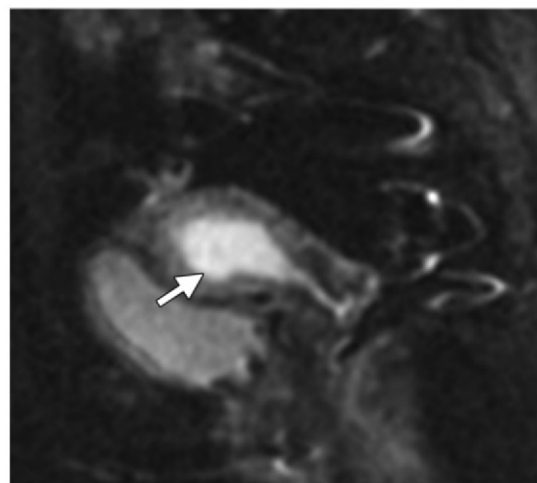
Stage IA endometrial carcinoma (grade 3 endometrioid adenocarcinoma) in a 51-year-old woman. (a) Sagittal T2-weighted MR image shows an intermediate- to high-signal-intensity endometrial tumor (arrows). It is difficult to distinguish the extent of myometrial invasion on T2-weighted images alone. (b) Sagittal T1-weighted MR image obtained after administration of intravenous gadolinium-based contrast material shows the endometrial tumor (arrow), which demonstrates relatively poor enhancement compared with that of the myometrium, which avidly enhances. (c) Corresponding diffusion-weighted MR image shows an area of high signal intensity within the endometrial tumor (arrow), a finding indicative of restricted diffusion. The tumor is seen to invade only the inner myometrium.
